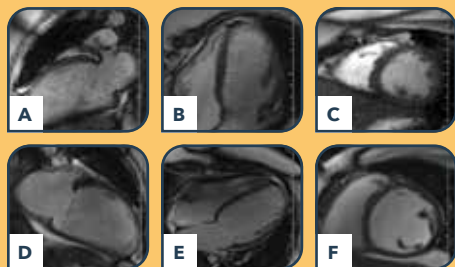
Cardiac Magnetic Resonance Images. (A-C) Cardiac MRI images showing normal size and function (A = 2 chamber, B = 4 chamber, and C = Mid-ventricle short axis). (D-F) One year later, showing severe enlargement and decline in heart function (D = 2 chamber, E = 4 chamber and F = Mid-ventricle short axis).
